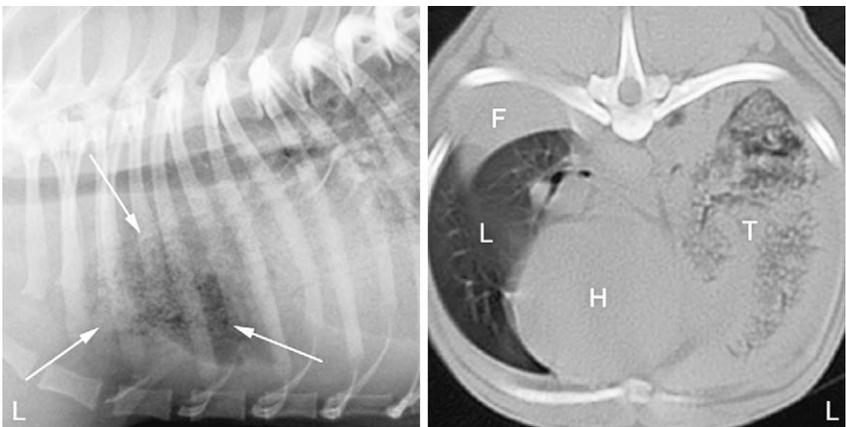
A lateral thoracic radiograph and CT scan of a 3-year-old, neutered male Pug with a left-cranial-lung-lobe torsion. Note that the left-cranial lung lobe is fully expanded with locally extensive increased opacity that contains innumerable, small, gas bubbles (arrows, T). This combination of signs is consistent with lung-lobe torsion with lung necrosis. The heart (H), lung (L) and pleural fluid (F) also are indicated.
